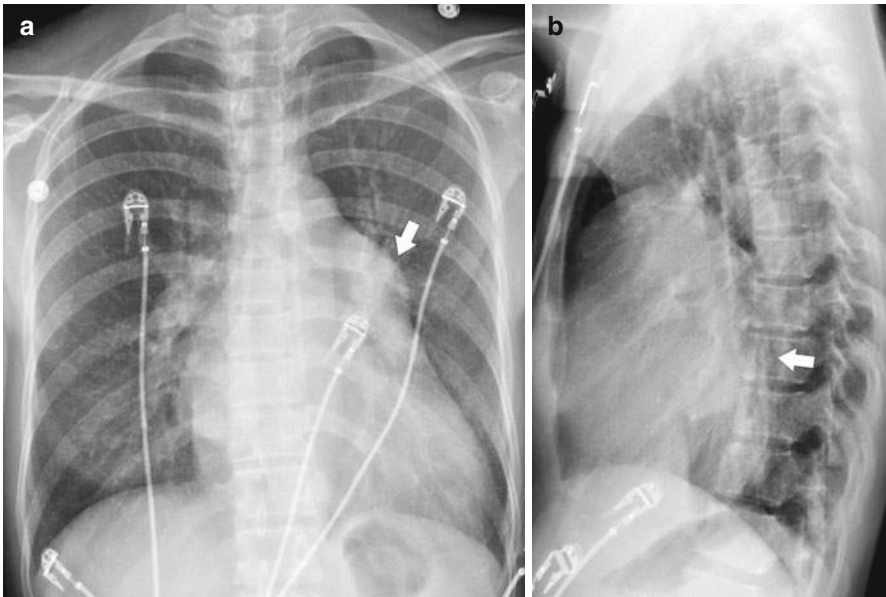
Mitral stenosis. Chest X-ray posteroanterior (a) and lateral (b) views show an enlarged left atrium (arrows)
